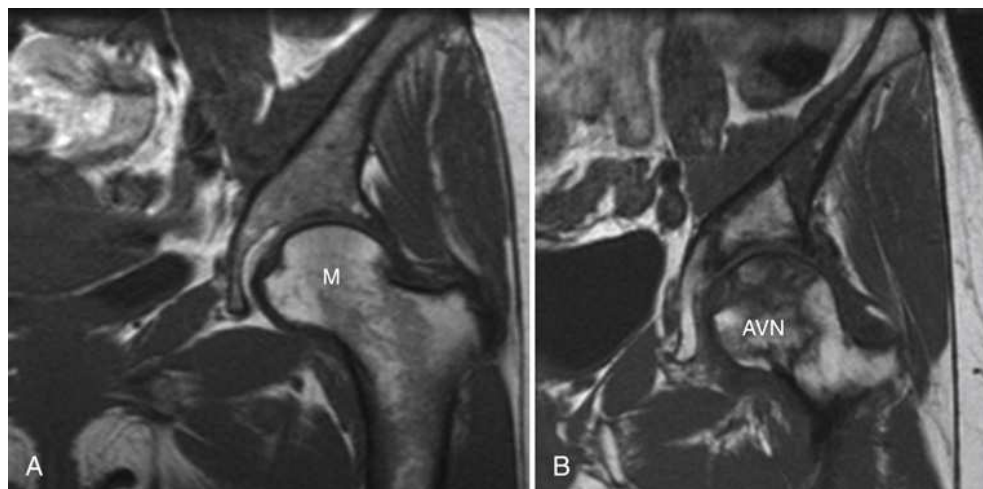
Two T1-weighted images of the left hip from different patients. (A) Normal bone marrow signal (*M*). (B) Abnormal bone marrow signal consistent with avascular necrosis (*AVN*).
